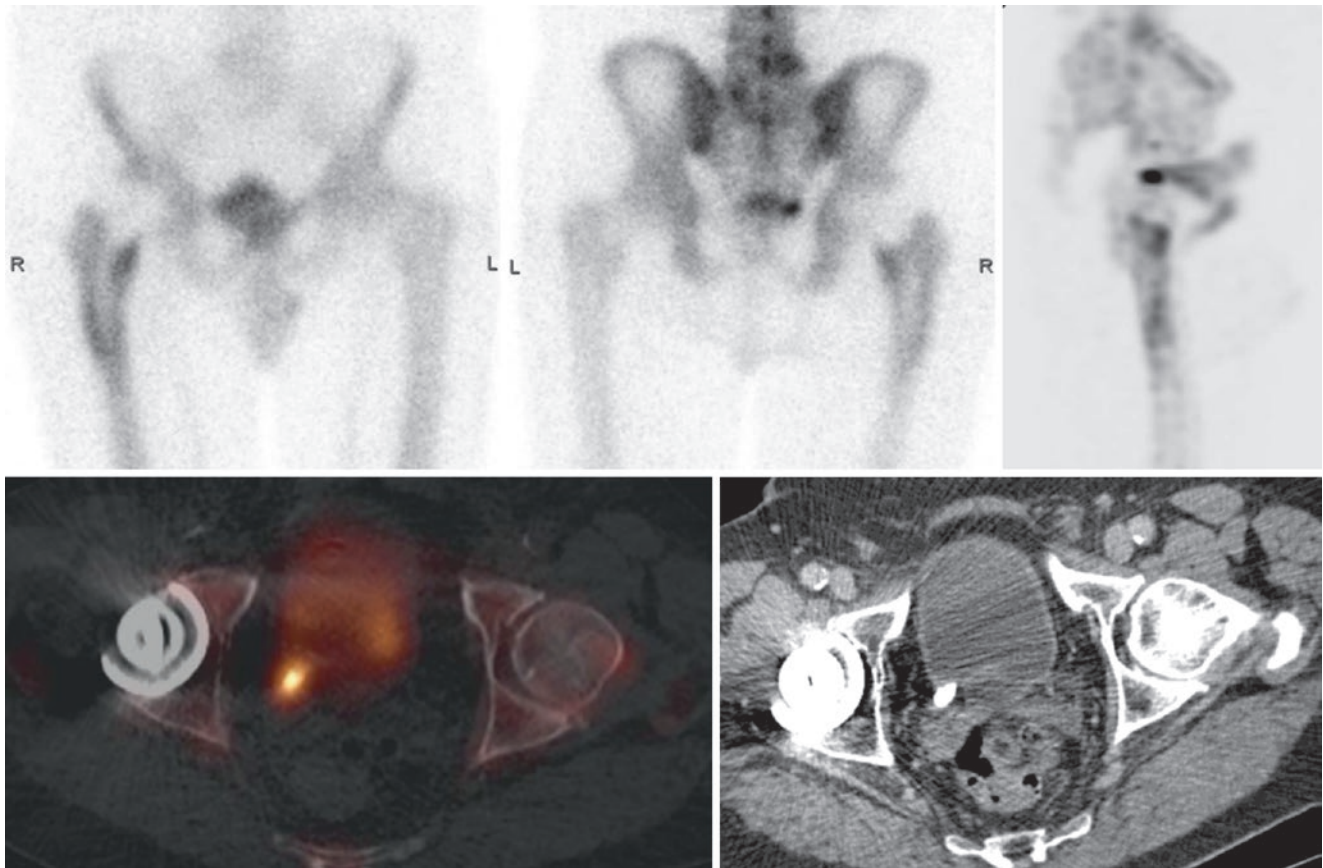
Patient for prostate cancer staging with focal increased uptake in the right pelvis. Lateral spot image shows that the uptake is probably not in the bone. SPECT/CT confirms uptake in a distal ureter concrement
